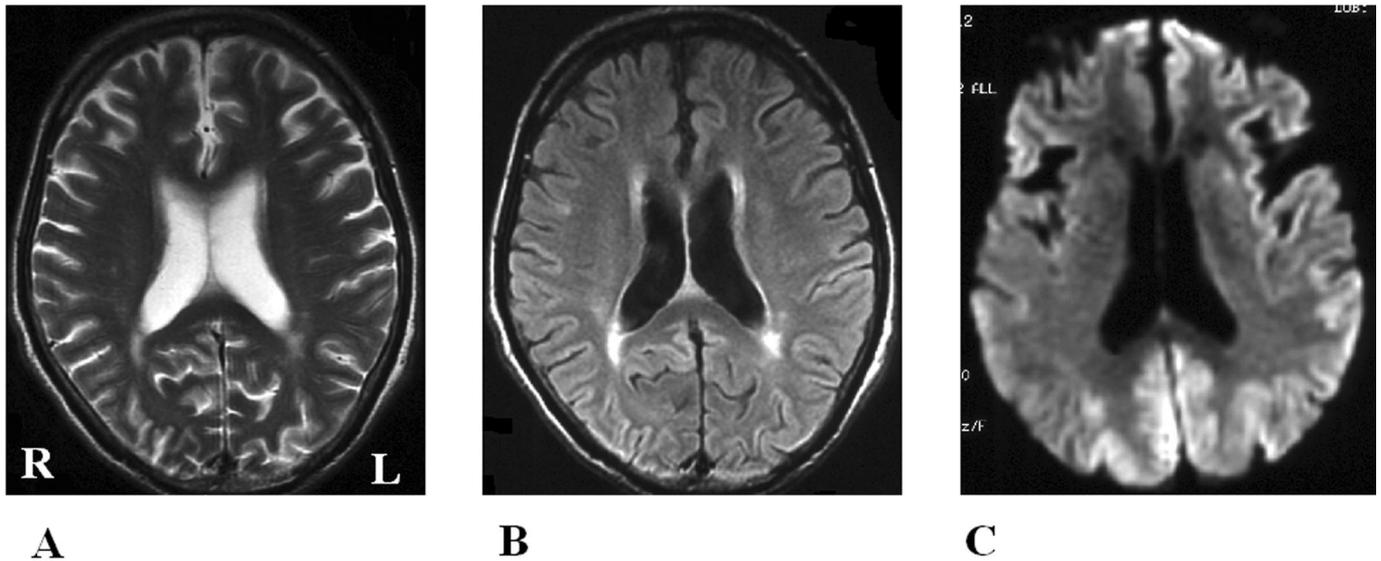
Comparison of conspicuity of Creutzfeldt–Jakob disease–related changes of the same patient on different MRI sequences. T2-weighted imaging (A) and fluid-attenuated inversion recovery imaging (B) show normal findings, and diffusion-weighted MRI (C) demonstrates high-intensity lesions in the cerebral cortex.
